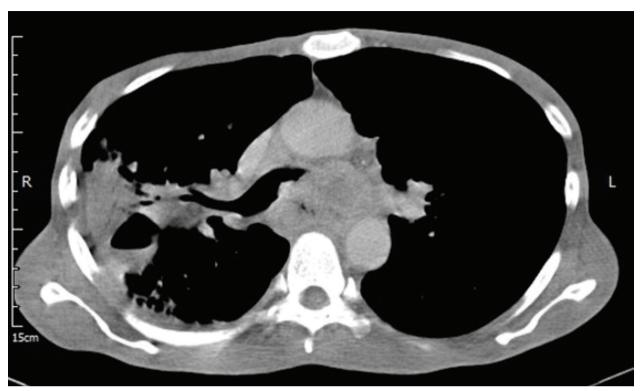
Chest computed tomography (CT) showed suspected esophageal cancer with a broncho-esophageal fistula and total obstruction of the left main bronchus.
